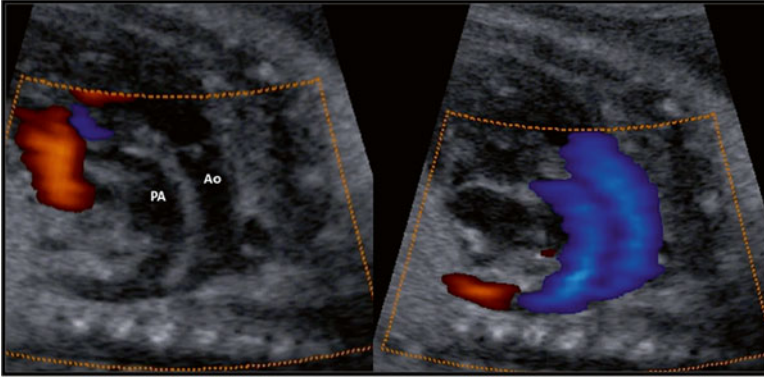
Fetal echocardiographic view of *transposition of the great arteries* with 2D-US (*left*) and color Doppler (*right*). Note that aorta and pulmonary artery run parallel to each other instead of crossing. *Ao* aorta, *PA* pulmonary artery
